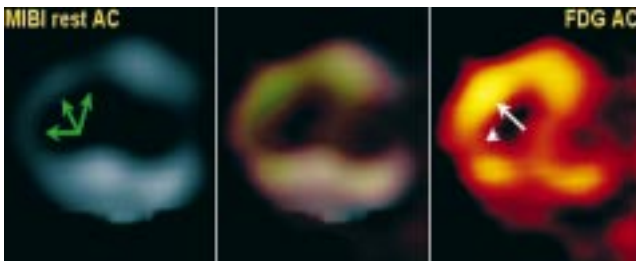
A vertical long axis plane of the left ventricle: Substantial hypoperfusion is clearly apparent in the apex and apical half of the anterior wall (green arrows on the left hand side). In the same region one can recognize glucose hypermetabolism (white arrow) representing a viable hibernating myocardium as well as hypometabolism (arrowhead on the right hand side) representing a nonviable myocardial scar. The image fusion in the middle is difficult to assess, because both modalities are of similar spatial resolution. All images are attenuation corrected; the quality of the FDG-PET is lower because of the generally low glucose myocardial uptake in a diabetic.
